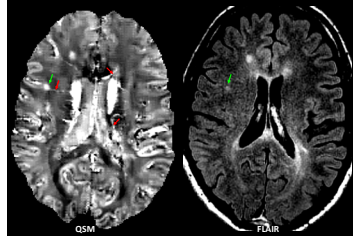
One gray and white junction MS lesion (green arrows) shown on QSM and faintly on FLAIR. In addition, QSM is able to show lesion-vein connections (red arrows)
